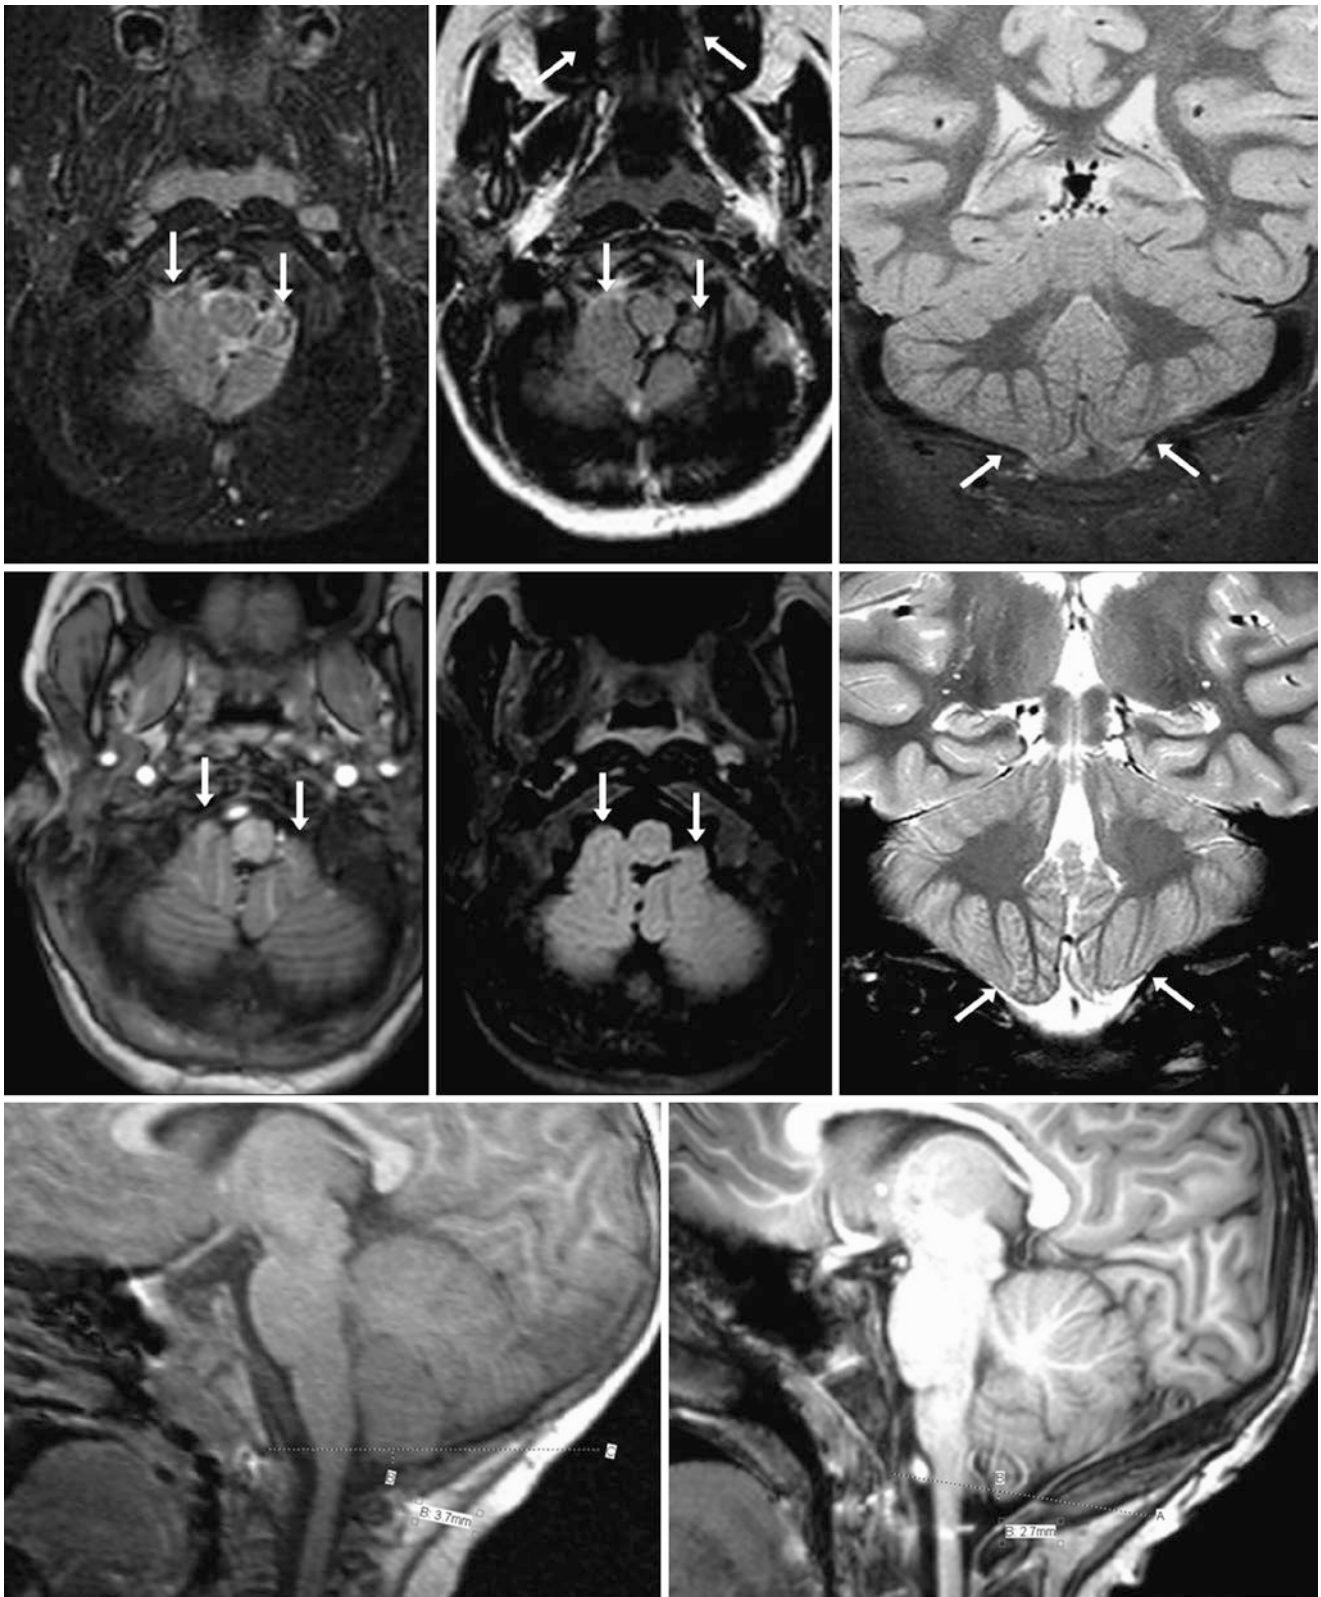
A 4-year-old child with mild tonsillar ectopia (arrows) on an otherwise negative 1.5 T MRI for developmental delay. *Top row:* on axial T2WI (left), FLAIR (middle), and coronal IR T2WI (right) there was mild tonsillar ectopia but a lack of mass effect (i.e., herniation) on the cervicomedullary junction, with CSF clearly seen surrounding it.
